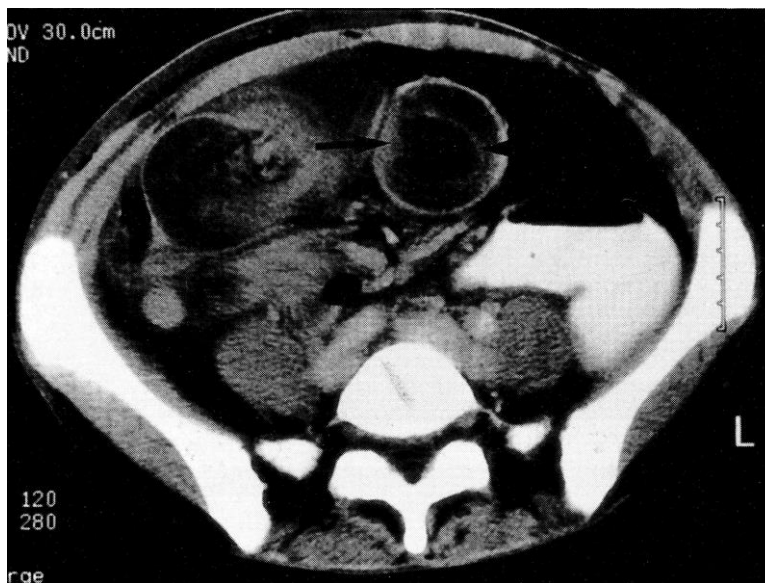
CT scan shows a typical target-shaped intussusception with low attenuation mesenteric fat (arrow) surrounded by high attenuation bowel wall.
